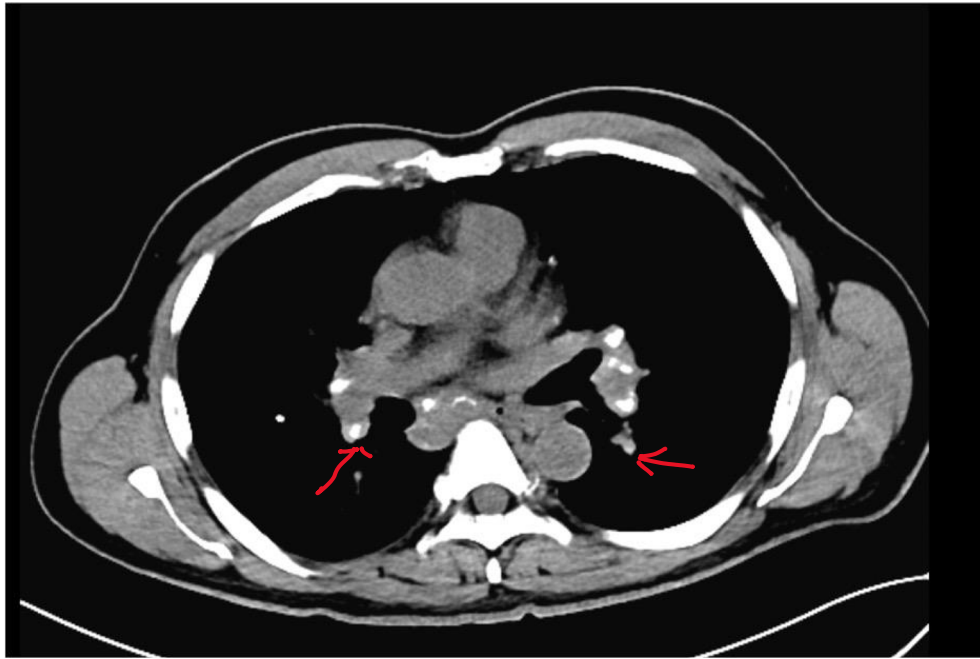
Abdominal CT scan showing adenopathy.
